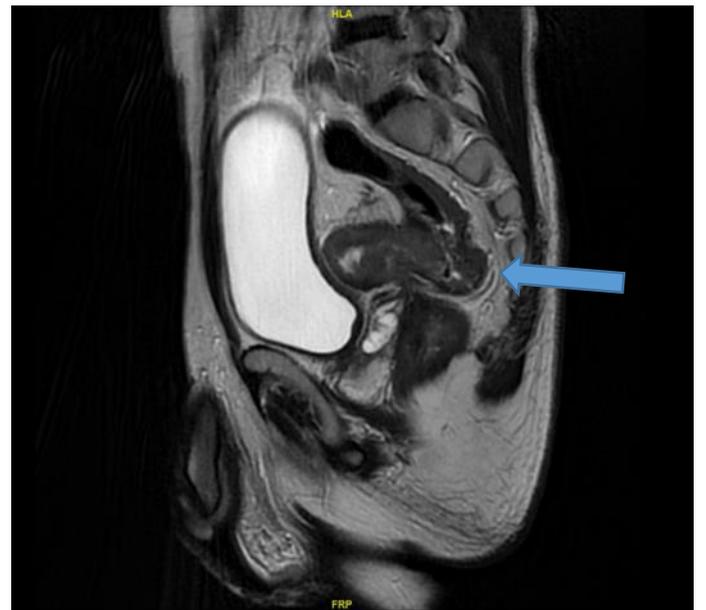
WB-MRI, pelvic T2-weighted sequence, irregular mass wall thickening in the rectosigmoid colon in the sagittal section (blue arrow).
